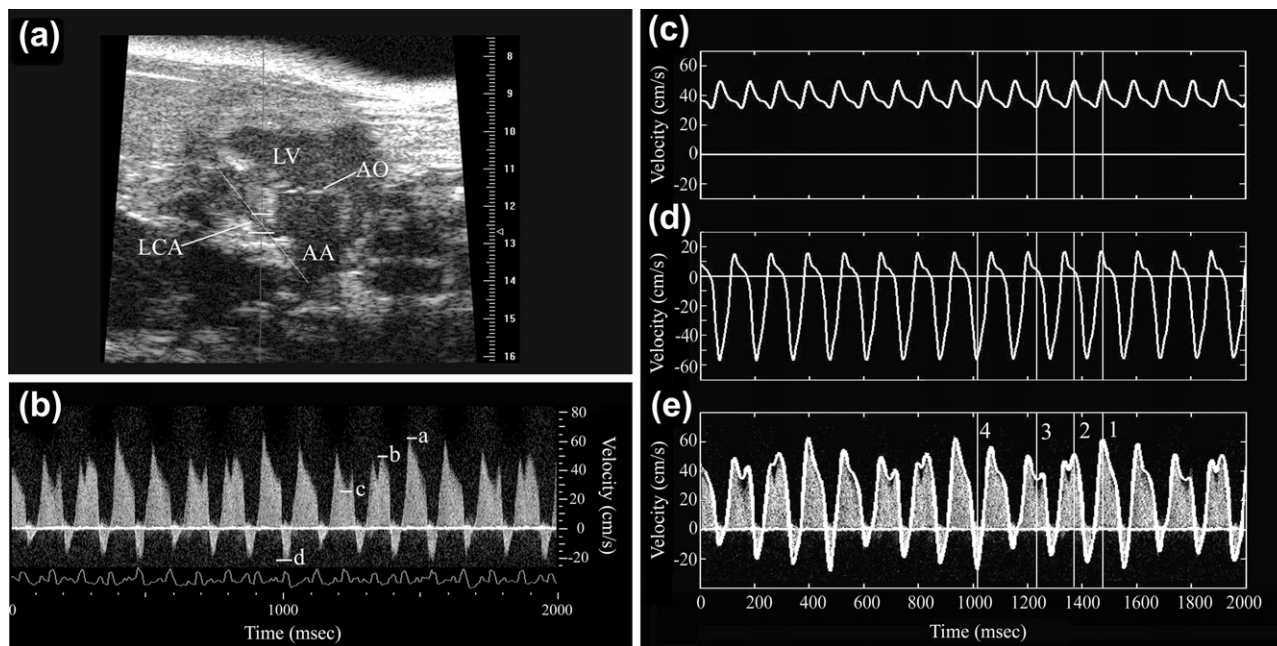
Flow pattern in left coronary artery (LCA) of an isograft and the method of analysis. (a) UBM image of LCA on day 50 postimplantation, showing the location of the Doppler sample volume. (b) Typical Doppler flow spectrum of the LCA with periodic variation of waveforms caused by asynchrony between the native heart and the isograft. To interpret the data, the waveform was decomposed into two periodic waveforms, as shown in panels (c) and (d) using numerical fitting. (c) The waveform representing the forward flow perfusing the myocardium of the graft, which is assumed to be caused by native circulation alone. (d) The waveform assumed to be produced solely by the activity of the cardiac isograft, with forward (positive) flow during ventricular relaxation and backward (negative) flow during ventricular contraction of the isograft. (e) The summed waveform of panels (c) and (d), which closely represents the real Doppler waveform shown in panel (b). In panels (c) to (e), line 1 marks the peak systole of the native heart and the maximal diastole of the graft, producing the maximal forward flow velocity (forward V_{\max}) as indicated by letter a in panel (b). Line 2 is at the peak systole of the native heart when the flow velocity caused by the graft is close to zero, resulting in moderate forward flow velocity as indicated by letter b in panel (b). Line 3 is at the end diastole of the native heart when the flow velocity produced by the graft is close to zero, yielding the notch with minimal forward velocity (forward V_{ed}) as indicated by letter c in panel (b). Line 4 is at the maximal contraction of the graft against the lowest forward flow at the end-diastole of the native circulation, producing the maximal backward velocity (backward V_{\max}) as indicated by letter d in panel (b). See previous figure legends for the definitions of other abbreviations.
